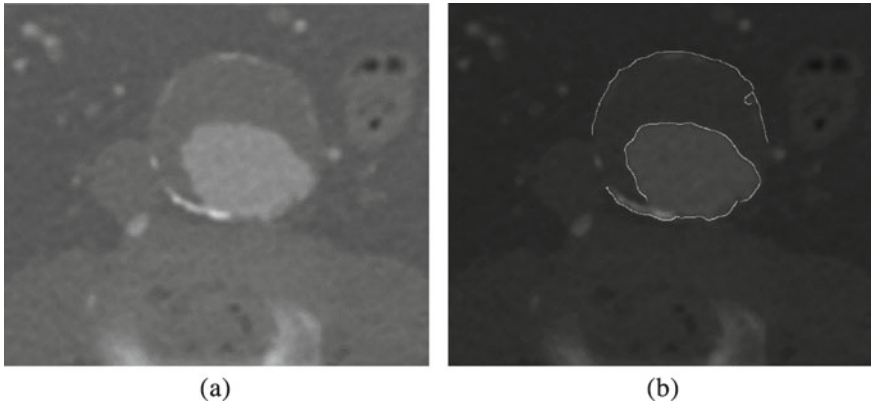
Example of Canny edge detection for guiding image segmentation of the abdominal aortic aneurysm from CT scans. a Original axial CT slice b CT slice with Canny edges (in white)
